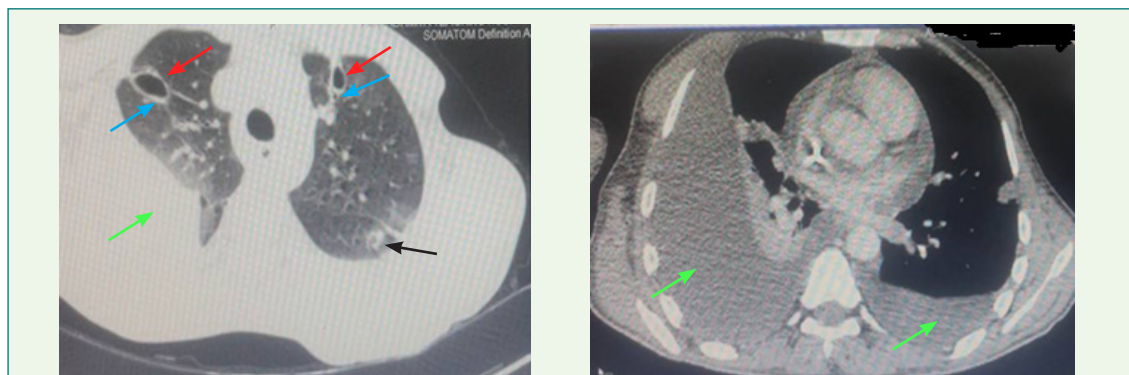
A: Non-contrast CT scan of chest with lung window shows 2 cavitary lesions involving both lungs' upper lobes anterior segments, red arrows, with surrounding ground glass opacity. The lesions have feeding arteries indicated by blue arrows. Another opacity appears in the upper segment of the left lower lobe, indicated by the black arrow. The green arrow indicates a right-sided pleural effusion. B: CT scan of chest (mediastinal window) shows bilateral pleural effusion (green arrow) mainly on the right side with collapsed right lung, and pericardial effusion.
